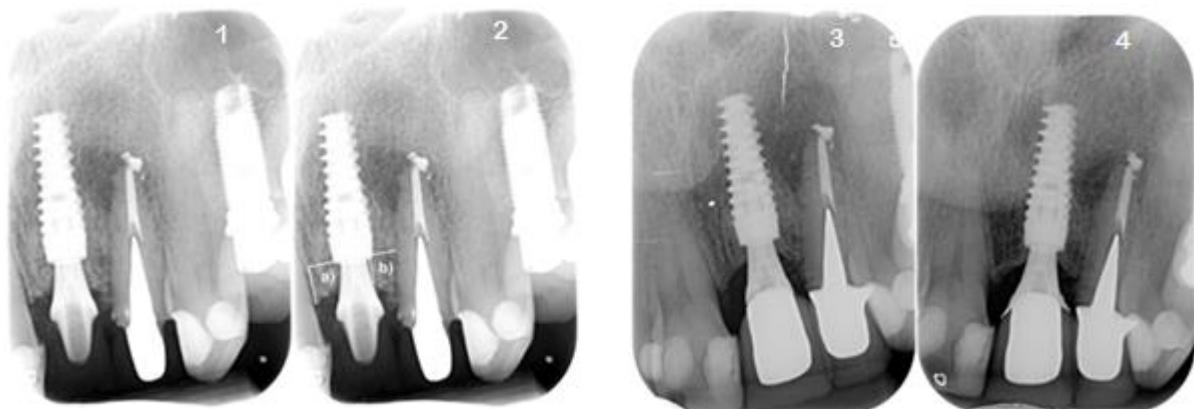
Demonstrating radiographs at the baseline (1, 2), at the 6 months follow-up (3) and at the final follow-up (4). Measurement of MBLN (a) and MBL (b).
